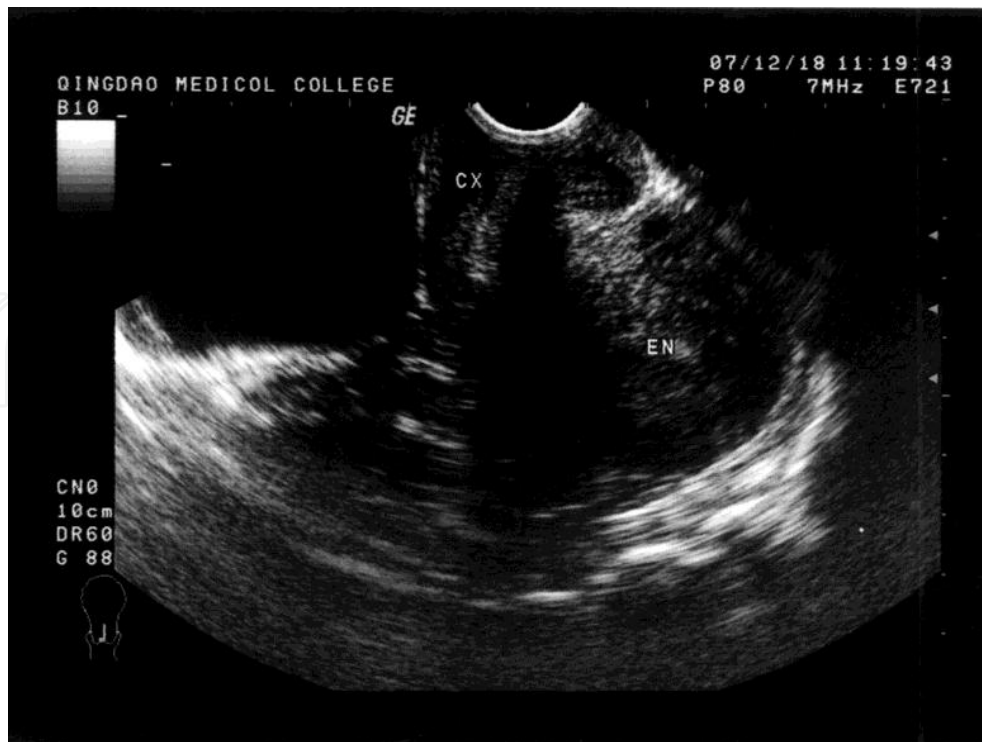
Tranvaginal ultrasound image of the cervical pregnancy after treatment. The same case as described in Figure 1. Eight days after treatment by UAE followed by curettage, the cervix recovered to normal in contour
